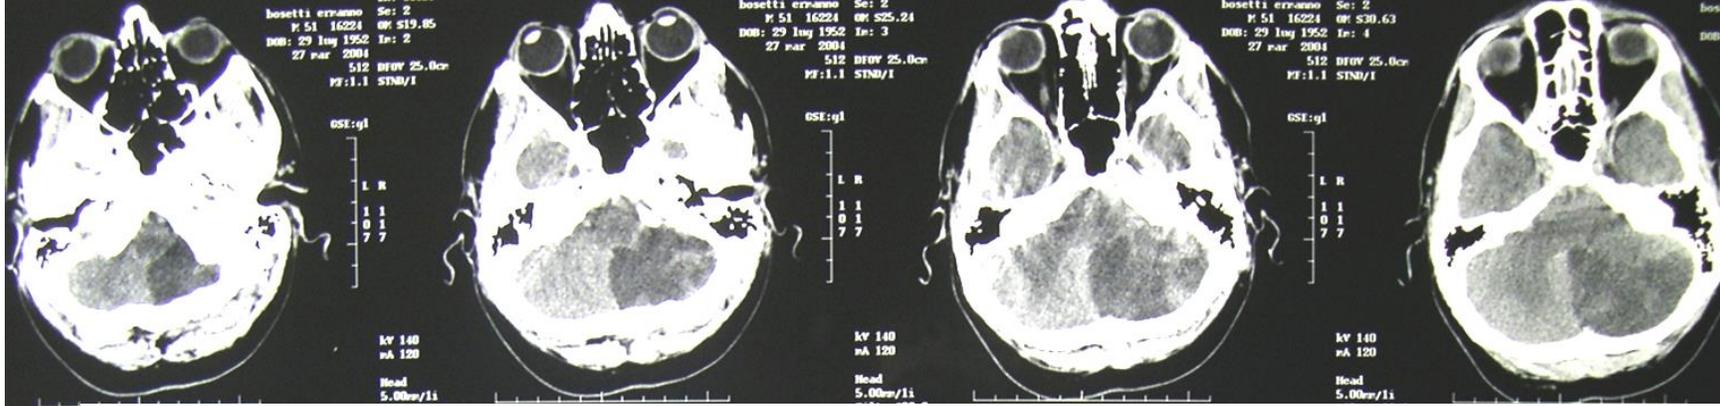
Serial CT scans of 2 CVST patients who died in the immediate postoperative period. Abbreviations: CT, computed tomography; CVST, cerebral venous sinus thrombosis.
